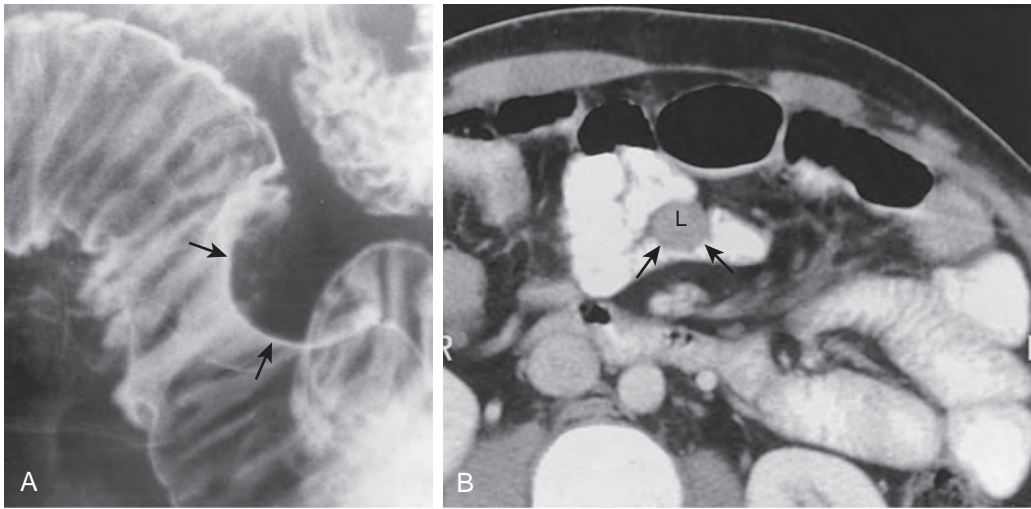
Gastrointestinal stromal tumor (GIST). A. The submucosal nature of the tumor is recognized on barium study by an area of semicircular mass effect on the lumen (arrows). The smooth surface results from stretching of the normal overlying mucosa. B. CT scan of the GIST (L) shows a smooth submucosal mass of homogeneous soft tissue (muscle) attenuation compressing the lumen (arrows).
